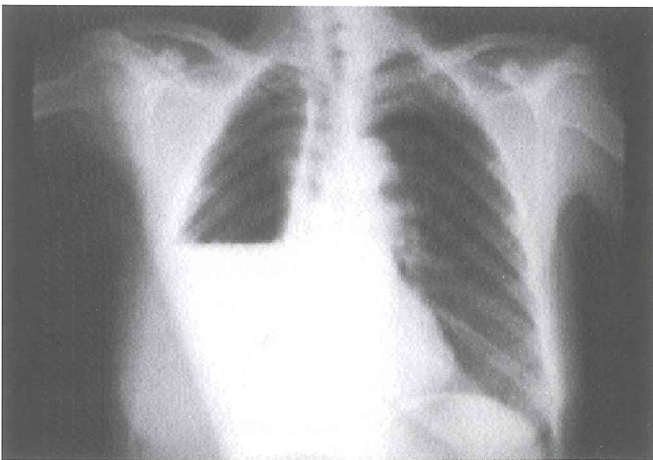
Chest x-ray showing the hydro-pneumothorax with total collapse of the right lung.
